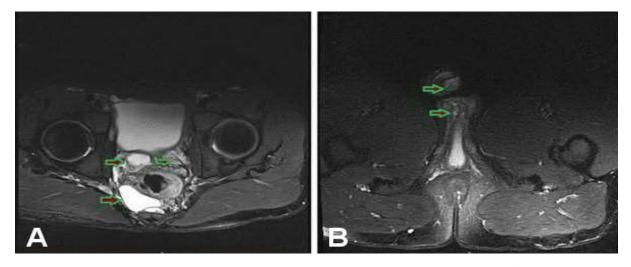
Repeat MRI after 13 months of Sirolimus therapy. A) Unchanged LM near rectum and obturator internus. B) Unchanged LM of glans penis and corpora cavernosa.
